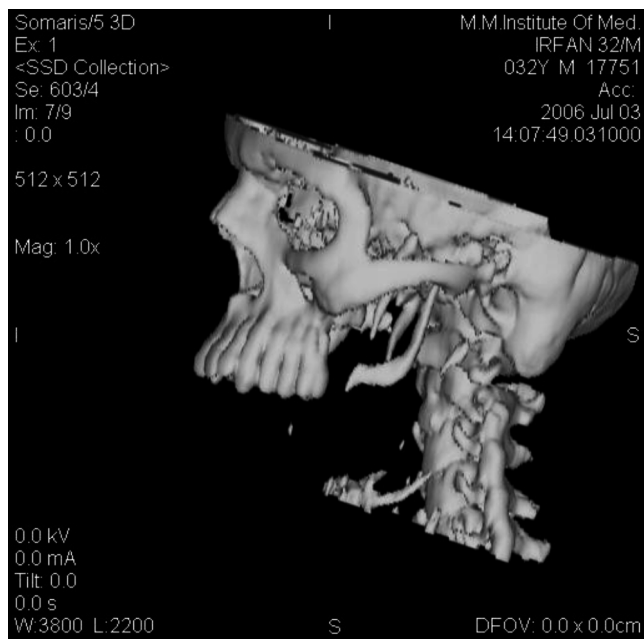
Three-dimensional CT image showing remnants of resorbed mandibular condyle.
